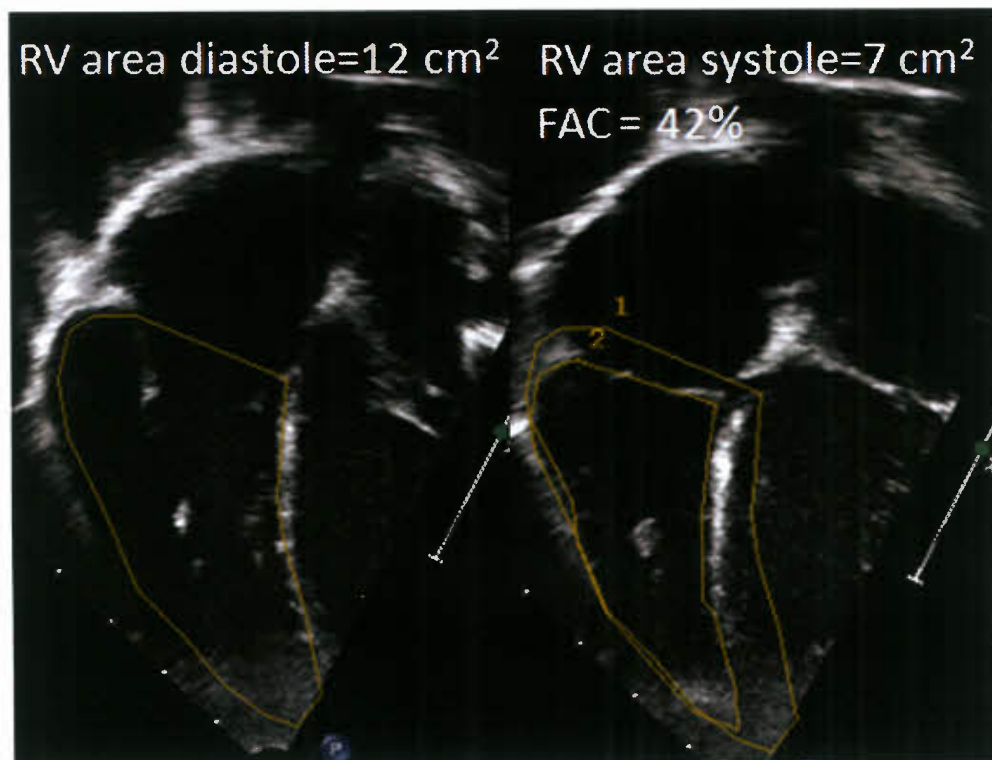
Right ventricular fractional area change (FAC). From the apical four-chamber view, the RV is imaged so that the endocardial borders can be tracked as well as possible. The RV area is measured at end diastole and at end systole and FAC is calculated as a percentage.
